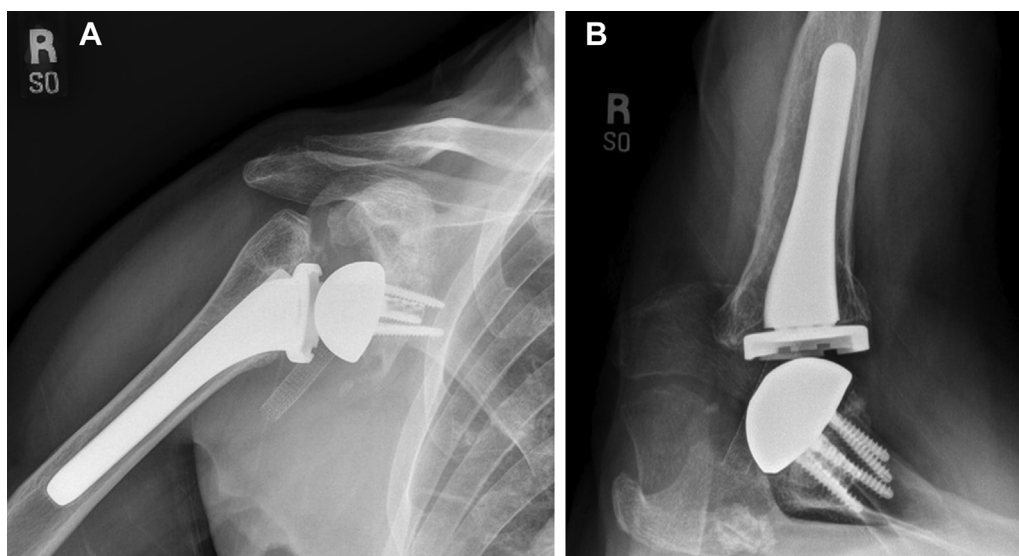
(A) Grashey and (B) axillary radiograph of the shoulder 2 years post-RTSA revision.
